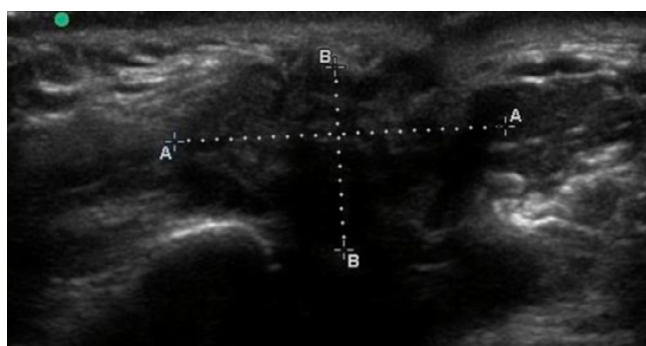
Malignant-appearing parotid lesion on ultrasonography, ultimately determined to be squamous cell carcinoma. Note the poorly defined borders and invasion into nearby parotid parenchyma, heterogeneous echogenicity, and lack of deep enhancement
